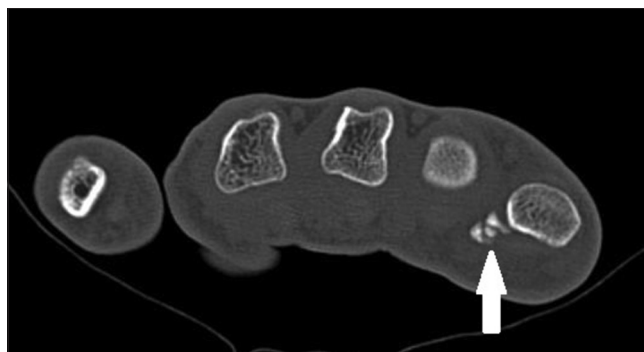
Computed tomography demonstrating fractured sesamoid (white arrow)
